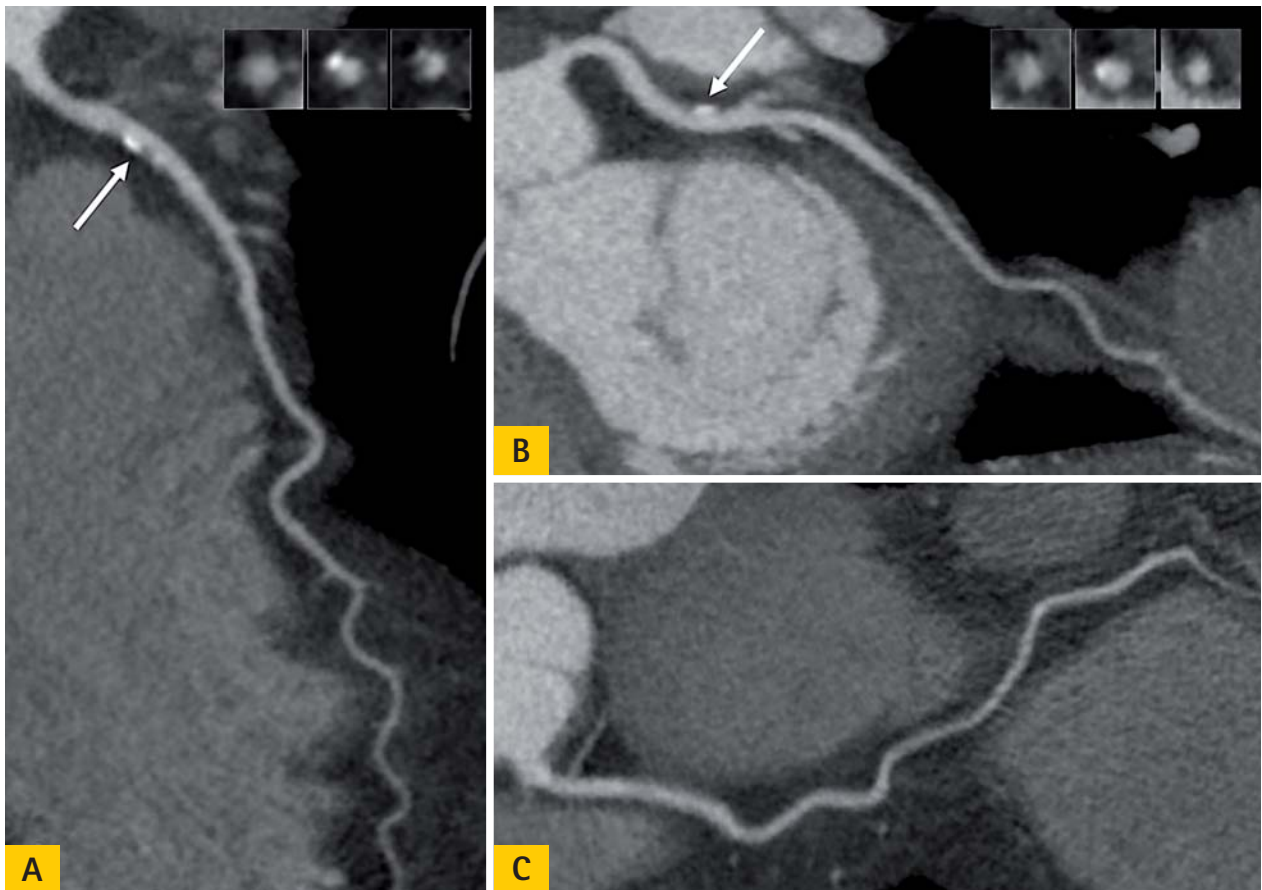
320-row dynamic volume CT coronary angiography of a 57-year-old male presenting with atypical angina pectoris, hypertension, history of smoking, and a positive family history of coronary artery disease. CT showed non-obstructive mixed plaques (a combination of non-calcified and calcified tissues within the same plaque) in the proximal left anterior descending coronary artery (A, arrow), and the proximal left circumflex coronary artery (B, arrow). Minor wall irregularities were observed in the right coronary artery (C).
